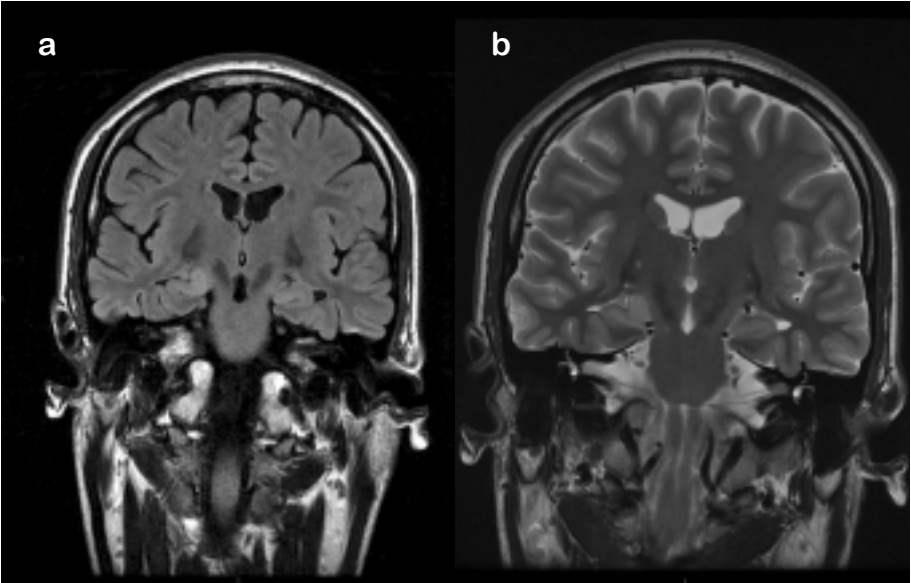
a) Coronal flair MRI. b) Coronal T2 MRI showing a right hippocampal signal change.
